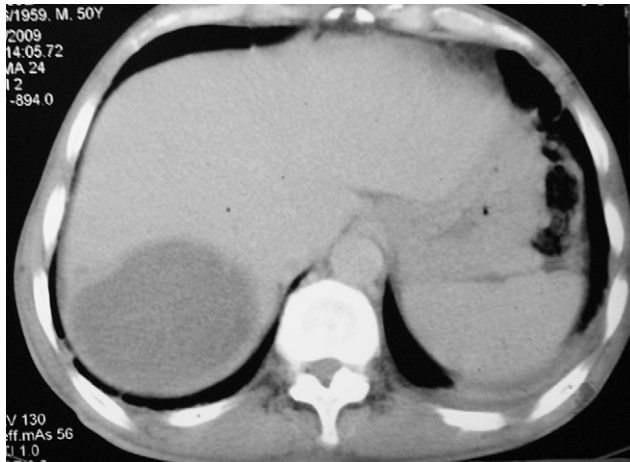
CT revealing a large hepatic lesion.
